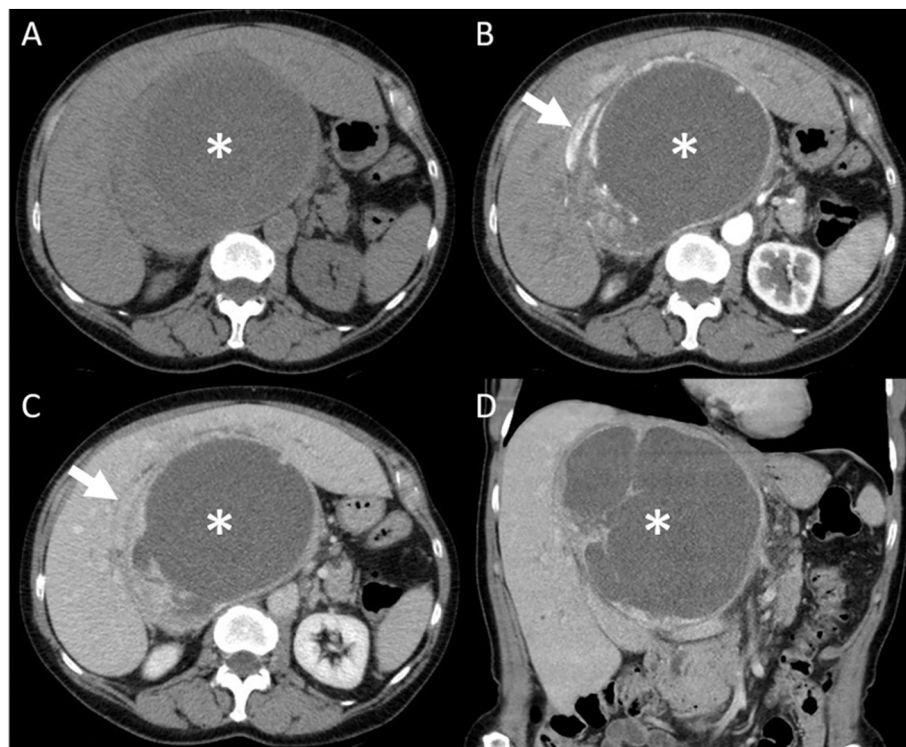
Pre-operative CT-scan. Native (A) and contrast-enhanced scans (B–D) in transversal (A–C) and coronar (D) sections. Asterisk marks the predominantly cystic tumor, the white arrow marks the severely displaced IVC.
